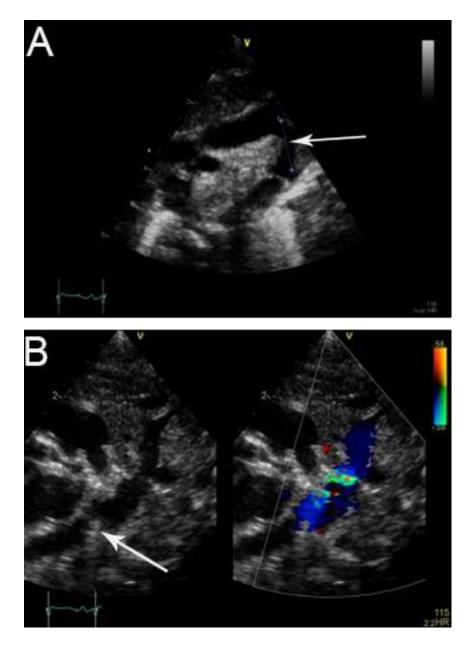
Echocardiographic parasternal window for arch assessment. A: The transverse arch length is measured by built-in tools (white arrow) B: CoA (white arrow).
